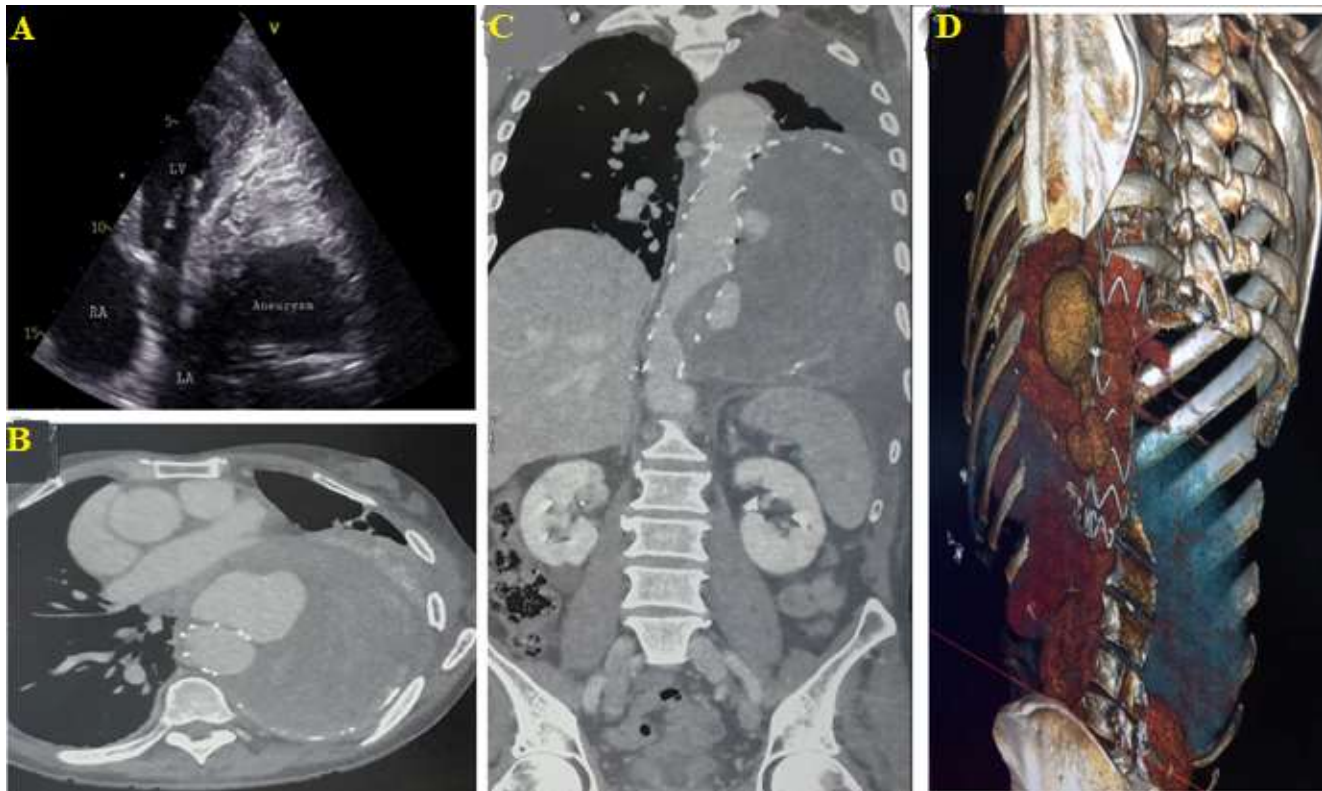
A) apical 4 chamber two-dimensional transthoracic echocardiogram showing compression of left cardiac chambers by descending thoracic aneurysm, with mural thrombus; B) contrast enhanced transversal computed tomographic imaging revealed eccentric saccular aneurysm of size 182 x 127 x 80 with mural thrombus arising from the arch and descending thoracic aorta, with compression of trachea, oesophagus and left cardiac chambers; C) contrast enhanced sagittal computed tomographic imaging revealed eccentric saccular aneurysm of size 182 x 127 x 80 with mural thrombus arising from the arch and descending thoracic aorta; D) three-dimensional abdominal angiographic CT scan showing peri-prosthetic descending aortic aneurysm
